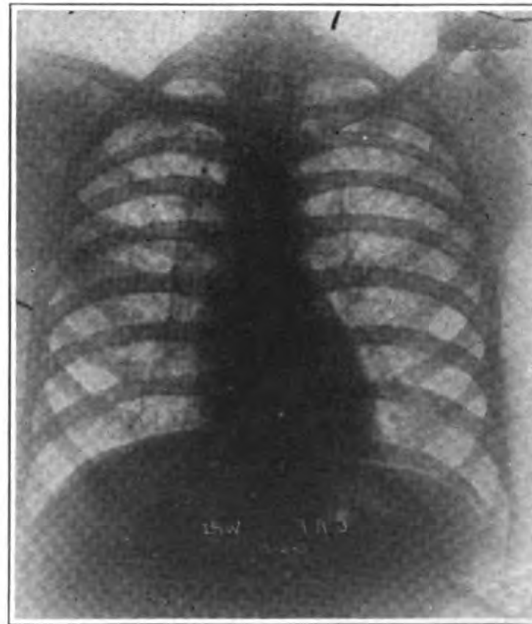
Fluoroscopic examination shows dullness of both apices; the right does not light up on coughing as well as the left; the hilus shadows are thickened and prominent, and the right diaphragm does not move as well as the left. The costo-phrenic angles are clear; the posterior mediastinal space is dull in its upper half. X-rays confirm fluoroscopic observation, showing fairly general active pulmonary tuberculosis throughout both lungs.
